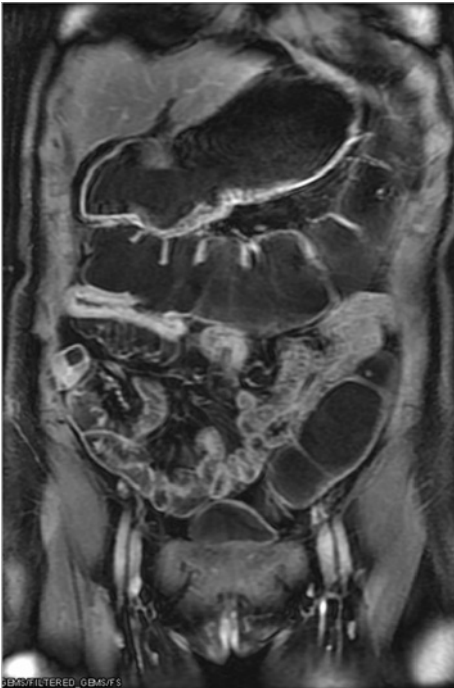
Coronal SPGR T1-weighted sequence after i.v. administration of a paramagnetic contrast agent: optimal detection of the length of the stenotic lumen
